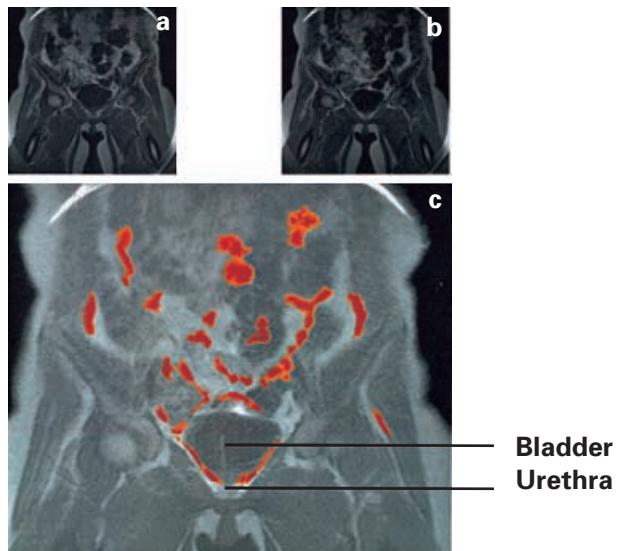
Superimposed MR images taken in the coronal plane (a and b) showing the supporting structures of the bladder. The red-coded regions (c) indicate the change in position of the levator ani during contractions.
